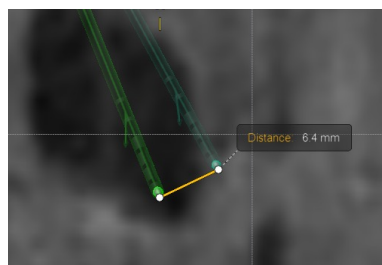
Lead displacement on coronal MRI T1 weighted image (BrainLab)
